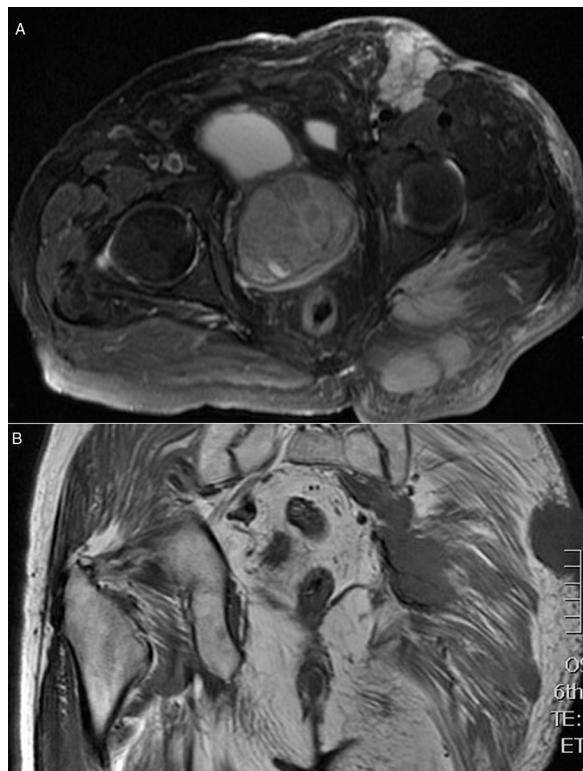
(A) Axial cut of MRI. (B) Coronal cut of MRI.
